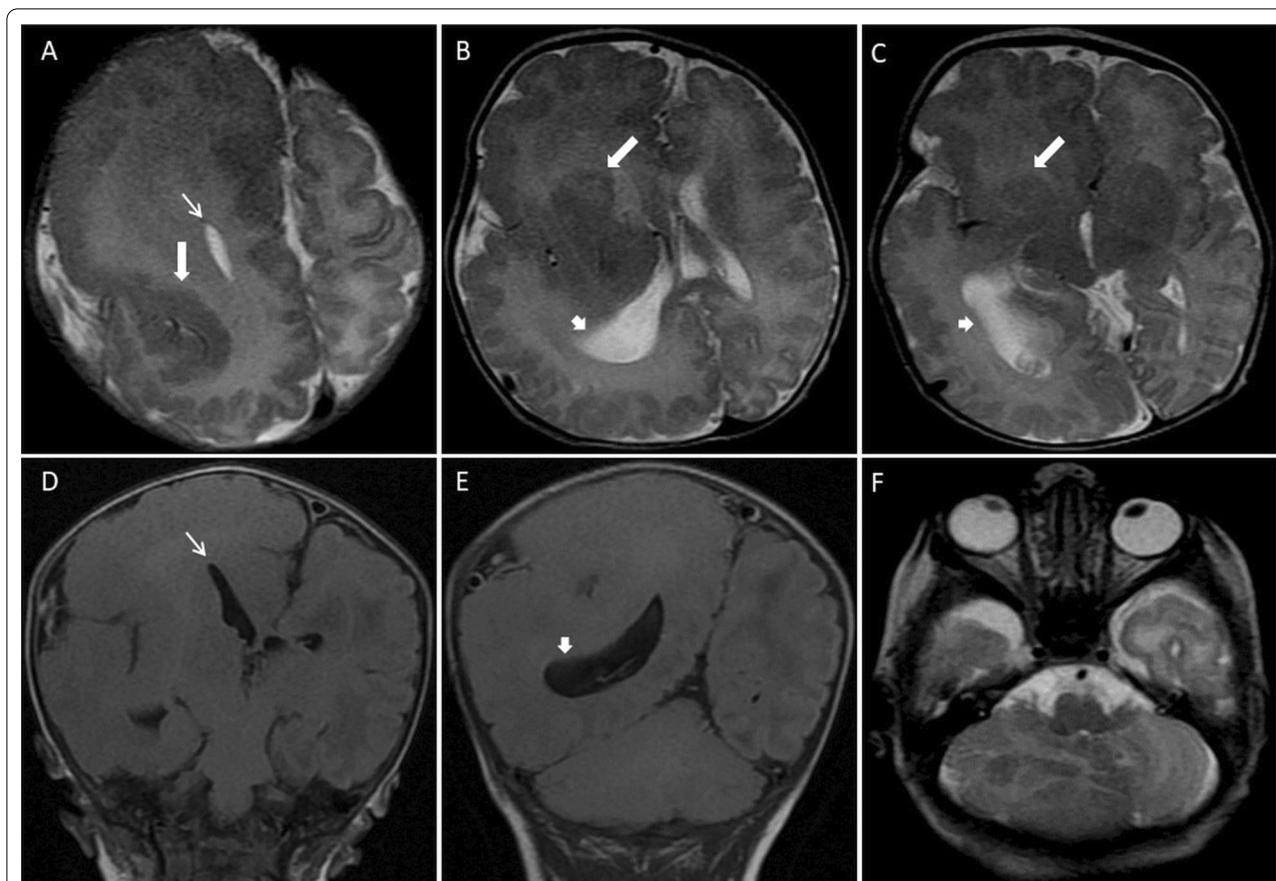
MR images of a 9-day-old male with West syndrome and epilepsy (a), (b), (c), and (f) axial T2-weighted; (d) and (e) coronal T2 fluid-attenuated inversion recovery (FLAIR) series with right total hemimegalencephaly, diffuse polymicrogyria and heterotopic grey matter foci on the right (thick arrows), upward angulation in the frontal horn of the lateral ventricle (thin arrows) and colpocephalic dilatation (arrowheads) in the occipital horn and right cerebellar dysgenesis is shown
